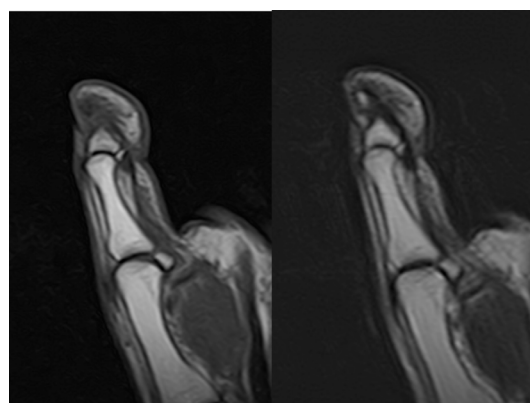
T1-weighted (left) and T2-weighted (right) magnetic resonance images of the distal phalanx of the right thumb.
